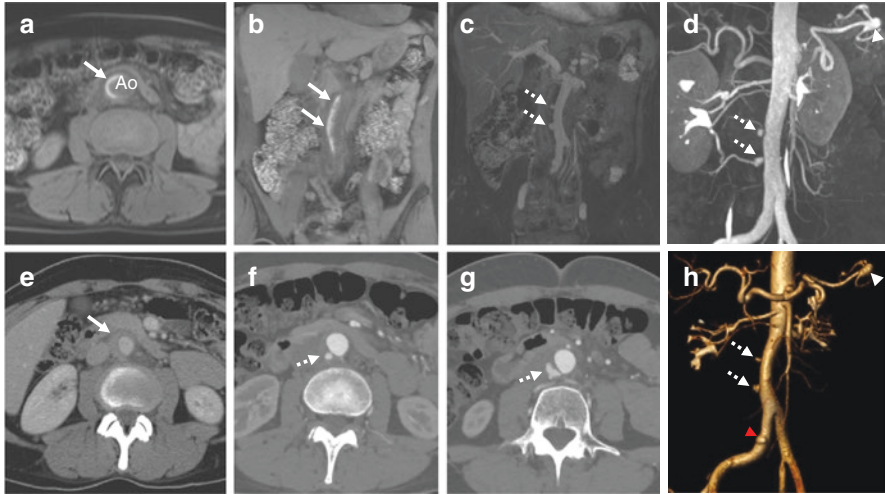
IMH of the abdominal aorta in a 45-year old woman with acute abdominal pain by MRI (a-d, h) and CT (e-g). Axial (a) and coronal (b) T1-weighted noncontrast MRI demonstrate crescentic high T1-signal in aortic wall (arrows) consistent with IMH. Subtraction postcontrast coronal T1-weighted imaging (c) shows no enhancement of the wall as well as small outpouchings (dotted arrows) representing intramural blood pools (IBP) which are pseudoaneurysms of lumbar arteries within the aortic wall. These IBPs are also evident on coronal oblique MRA maximum intensity projection (MIP) (d) and shaded-surface display (SSD) (h) reconstructions that also show aortic narrowing but that—as luminograms—do not show the IMH itself. Also noted on the MRA images is an incidental 1.8 cm splenic artery aneurysm (arrowheads). Note also that a right common iliac artery ulcer-like projection (ULP) is evident on the SSD (red arrowhead). CT images obtained a few days earlier also show the IMH (arrow) and IBPs (dotted arrows)
